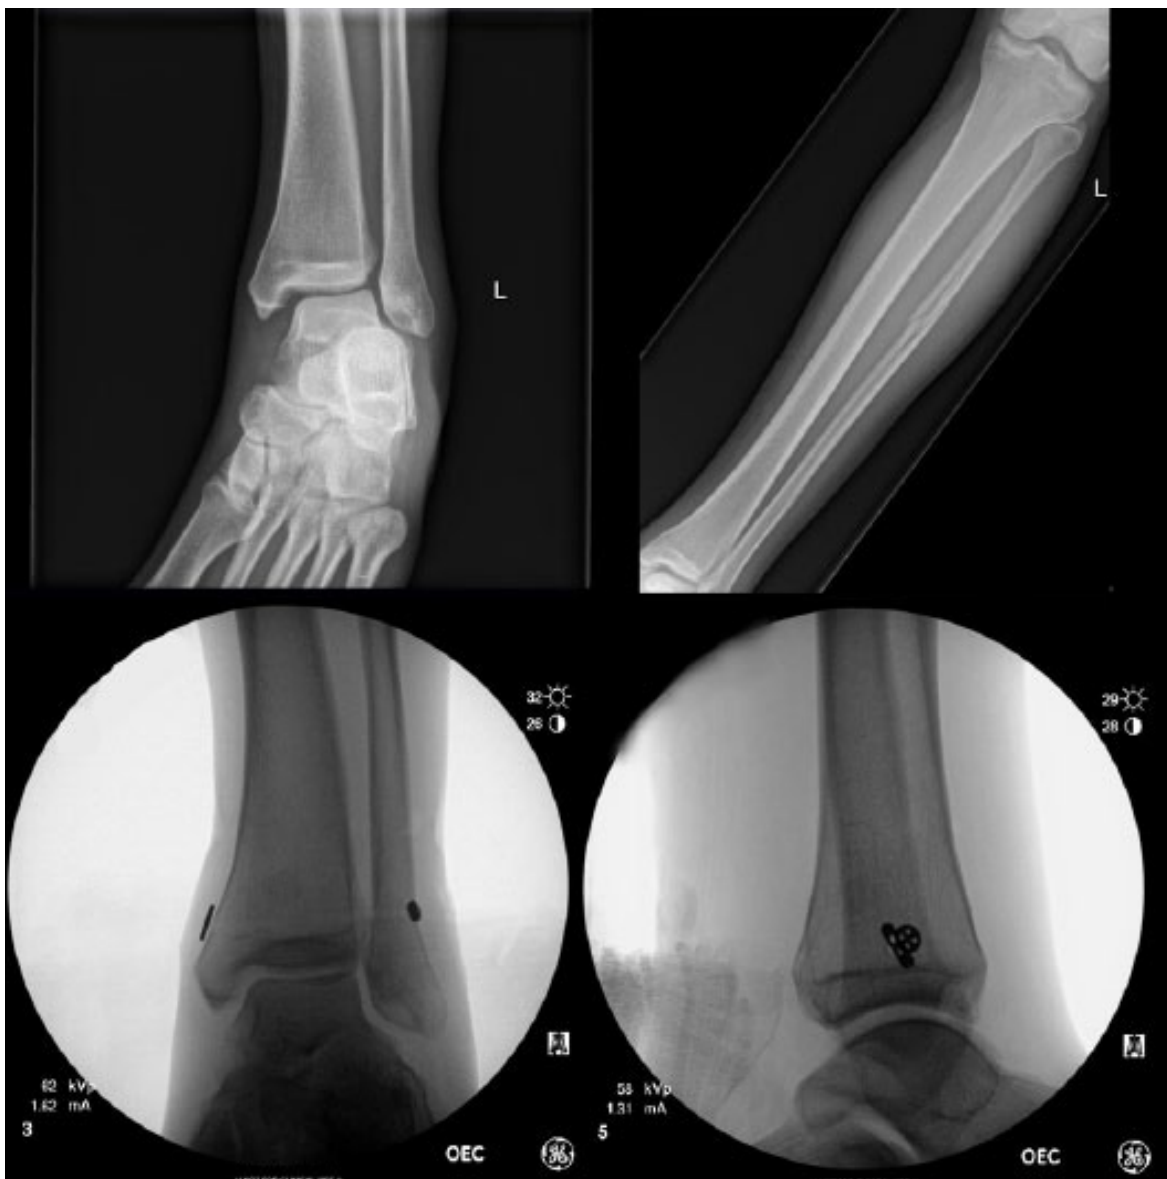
Top: Injury radiographs of a patient with a Maisonneuve injury. Bottom: Intraoperative fluoroscopic images of suture-button fixation of the syndesmosis.
